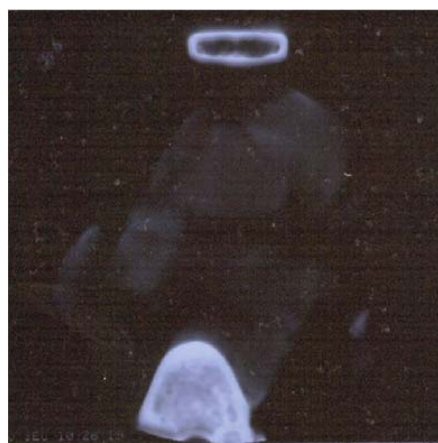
Thymus persistent detected by computed tomography (CT) increased thymus in patients thorax. By suspected myasthenia gravis thorax CT should be done due to thymus persistent or thymoma.
